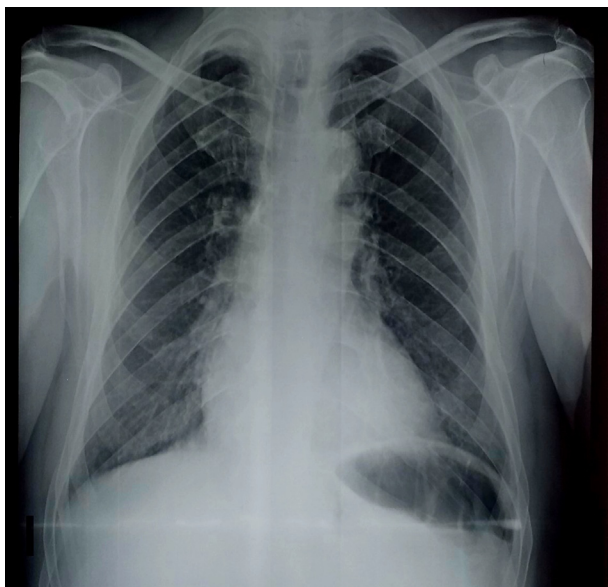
Preoperative chest X-ray revealed aortic calcification only in the aortic knuckle with no evident calcification of the ascending aorta.
